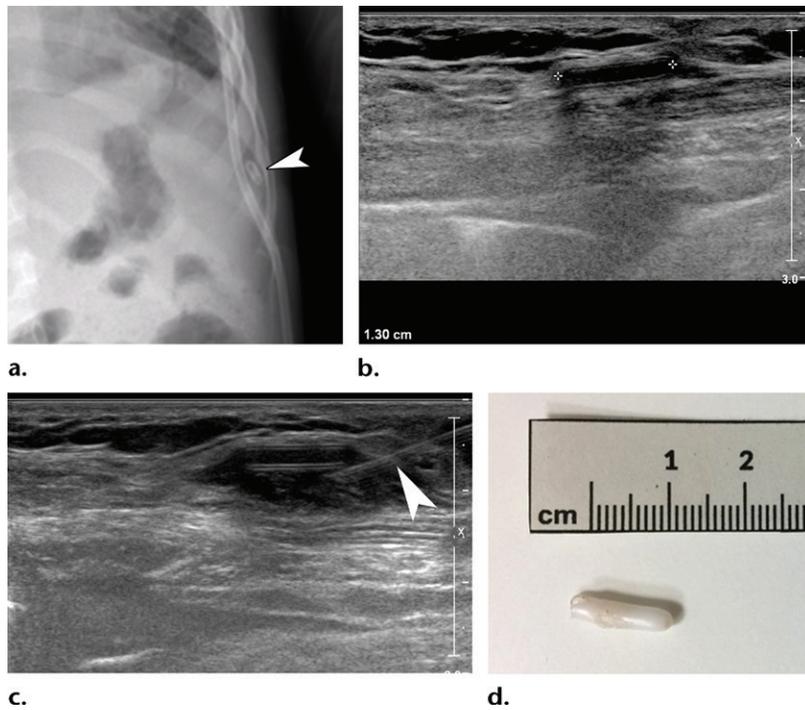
Foreign body in an 8-year-old boy with left pleural effusion who underwent a second pleural drainage after a failed first attempt. (a) Posteroanterior chest radiograph obtained after pleural drainage shows a fragment of a pleural catheter (arrowhead) in the ninth left intercostal space. The tip of the pleural catheter was accidentally cut during the first attempt. (b) US image of the left chest wall shows the catheter fragment depicted as two parallel 1.3-cm lines in the subcutaneous tissue. (c) US image shows the removal procedure, which began with placing a needle (arrowhead) next to the catheter to administer a local anesthetic around the foreign body. Movie 5 demonstrates the removal procedure. (d) Photograph shows the removed foreign body.
